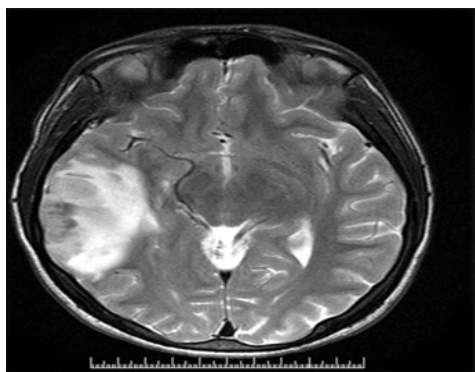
Axial T2 weighted MRI sequencing showing intracerebral hemorrhage in the right temporoparietal lobes.
